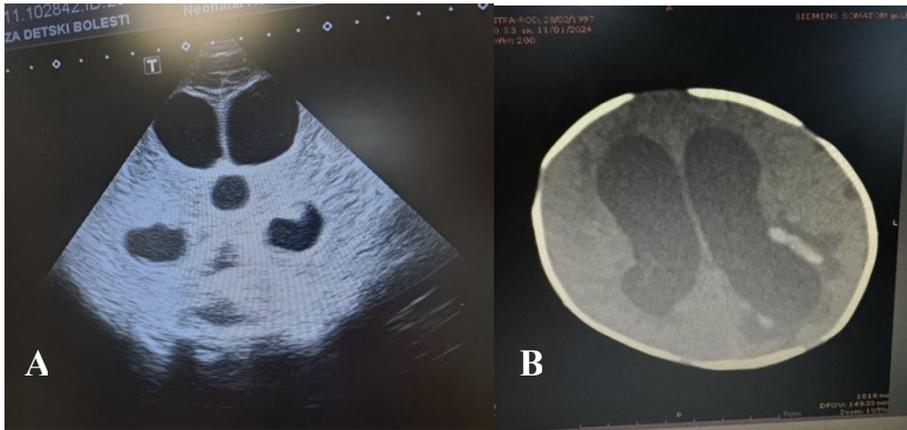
Neurosonography and brain CT prior to neurosurgical intervention
